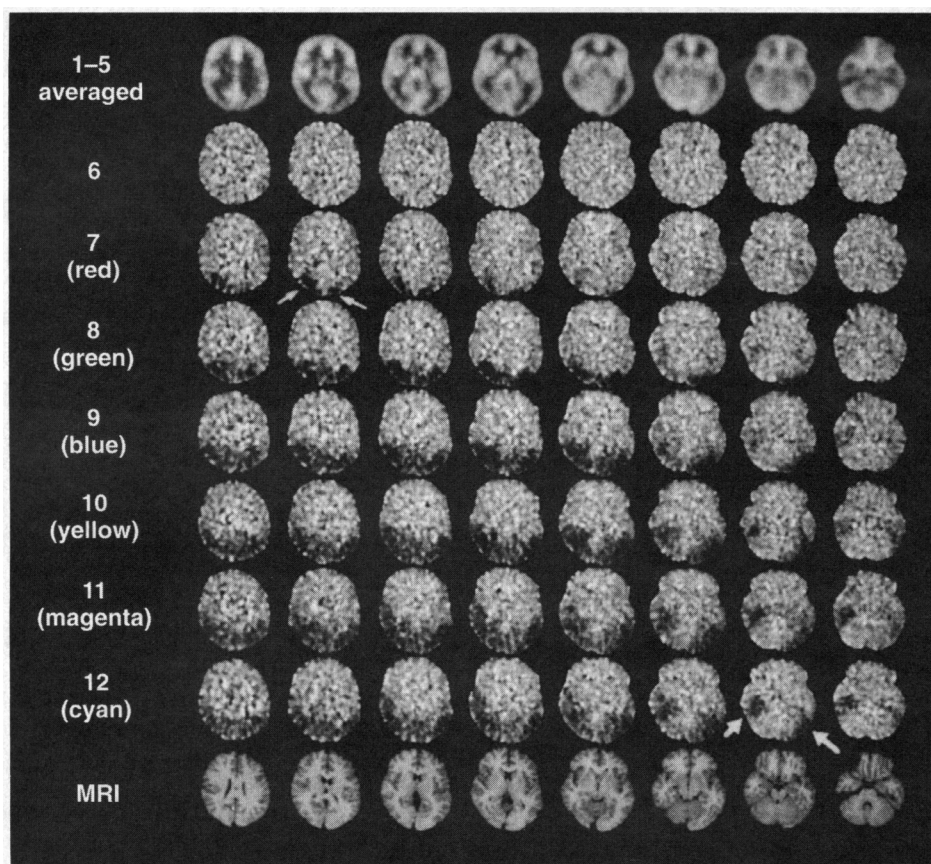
PET and MRI Scans of Blood Flow in the Brain of a Woman with Migraine Headache.
